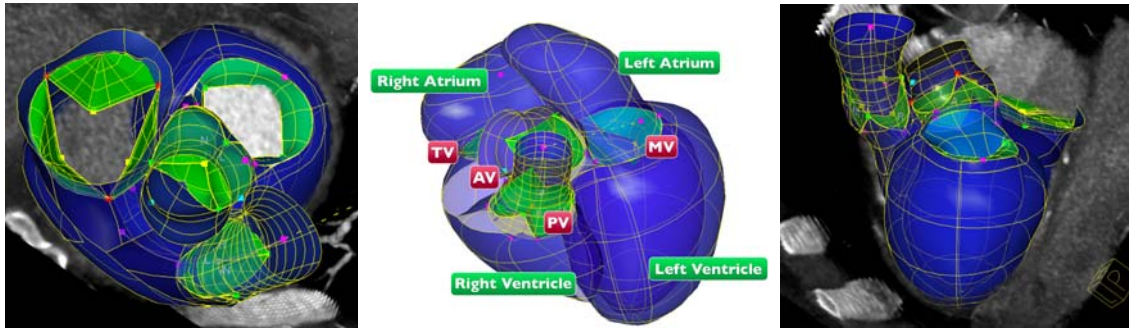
Examples of the full heart estimation from cardiac CT.
